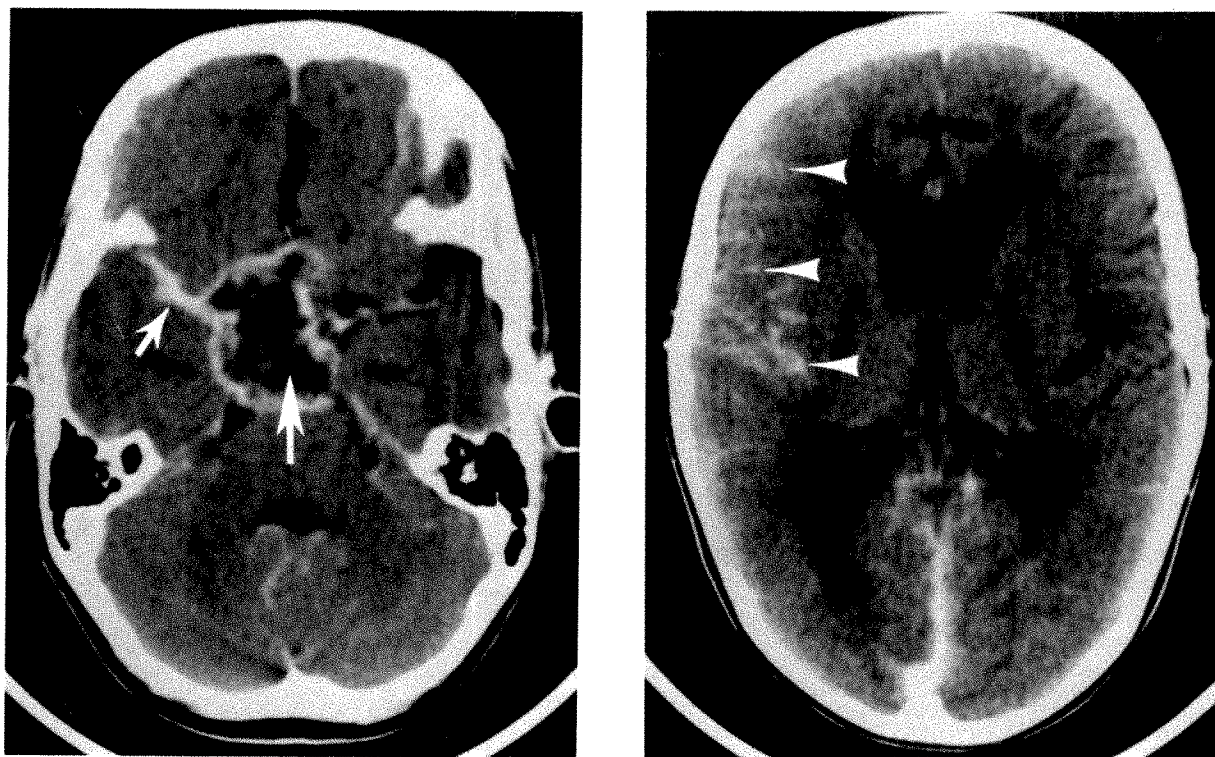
(Bruggers and associates). Case 1. Noncontiguous images from contrast-enhanced cranial computed tomographic scan show enhancing cystic suprasellar mass (large arrow) with contiguous extension into the right sylvian cistern (small arrow) and throughout the right hemispheric sulci (arrowheads).
